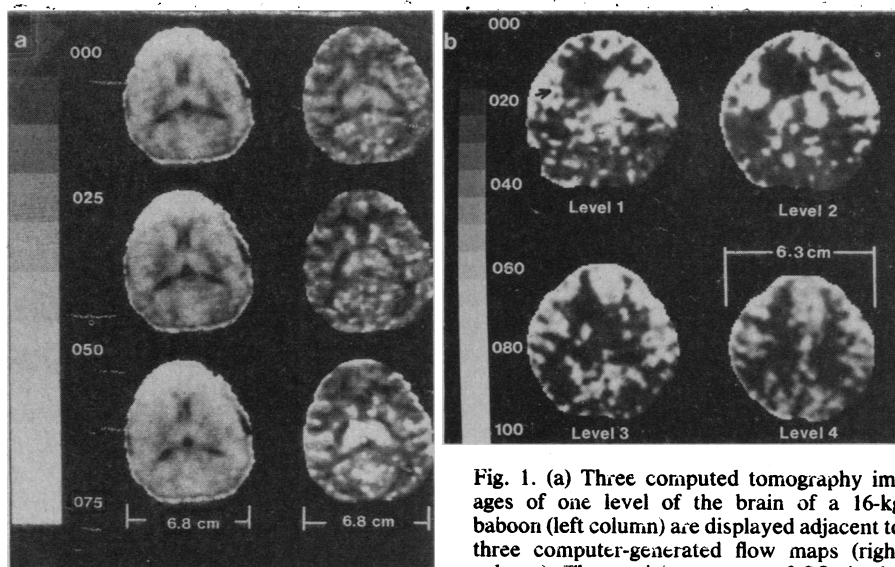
(a) Three computed tomography images of one level of the brain of a 16-kg baboon (left column) are displayed adjacent to three computer-generated flow maps (right column). The partial pressures of CO_2 in the upper, middle, and lower images, respectively. Elevated blood flow in various locales, mostly gray matter, with increased CO_2 concentrations are readily observed. The gray scale is given in milliliters per 100 g per minute. (b) Multilevel blood flow maps of four adjacent brain sections (5 mm thick) of a 9.8-kg baboon 19 days after infarction (arrow). Level 4 is above the infarcted area. All four sections were studied during a single inhalation.
